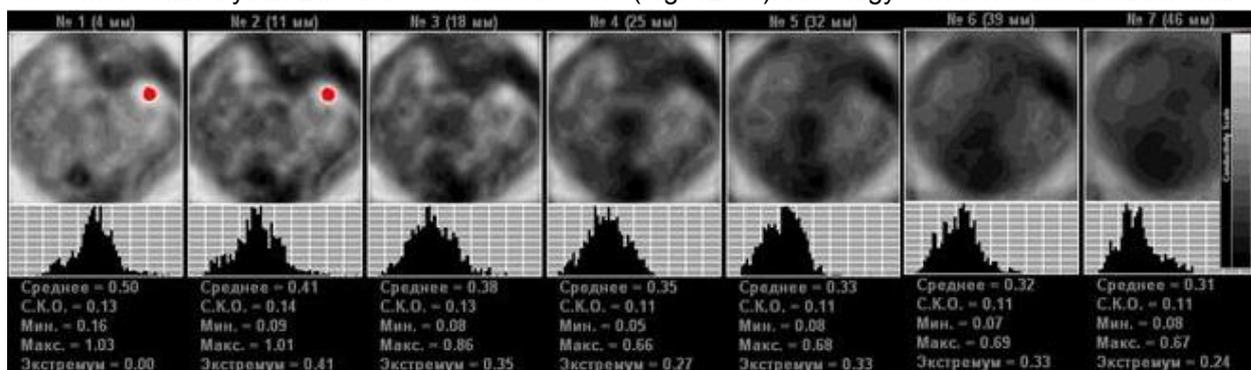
EIM. Upper segment. Mixed type of mammary gland structure. In the upper-outer segment of the right gland there is observed an an-impedance area, which is highlighted with red in two scan planes, 20x20 mm in size. ULTRASOUND: In the inner segment of the right gland at 1 o'clock position, there is an irregular shaped lesion with blurred contours and vascularization, approximately 2.0 cm in size. Roentgenogram: A 3 cm lesion with a radiating contour and calcification is located in the right gland.
